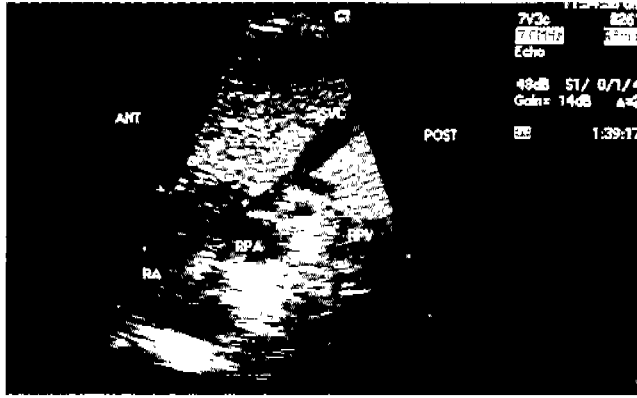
Preoperative transthoracic echocardiography in Patient 3. Anomalous pulmonary vein from right upper lobe is connected to the small right SVC. SVC, superior vena cava
